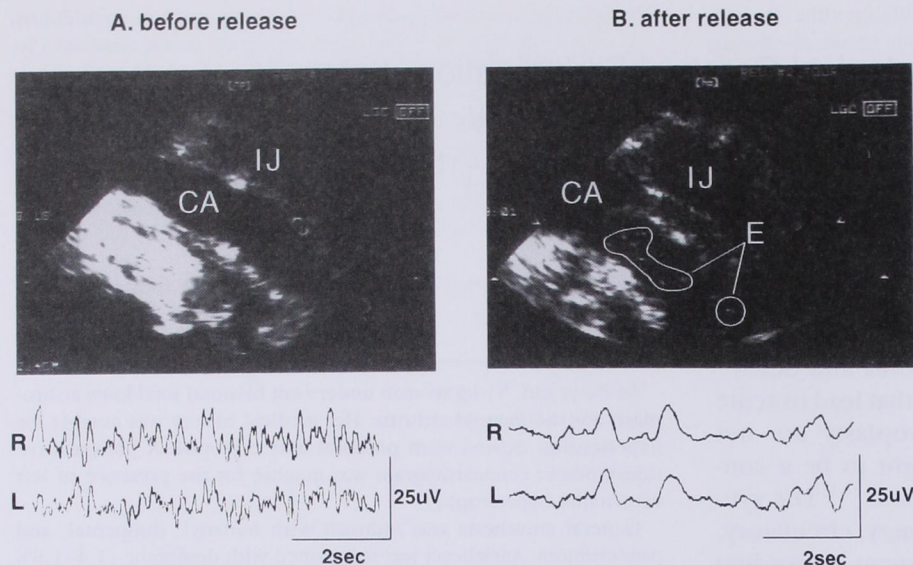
Representative ultrasound images of the right carotid artery (*top*) and right (R) and left (L) prefrontal-to-frontal (Fp1-F3) electroencephalographic (EEG) waveforms (*bottom*) obtained shortly before (A) and after (B) release of the second tourniquet. After deflation of the second tourniquet (B, *top*), multiple intravascular emboli (E) were observed in the carotid artery (CA) but not in the internal jugular vein (IJ). Release of the second tourniquet was also associated with marked bilateral slowing and reduction of fast EEG activity (B, *bottom*) as compared to the EEG activity before tourniquet deflation (A, *bottom*).
